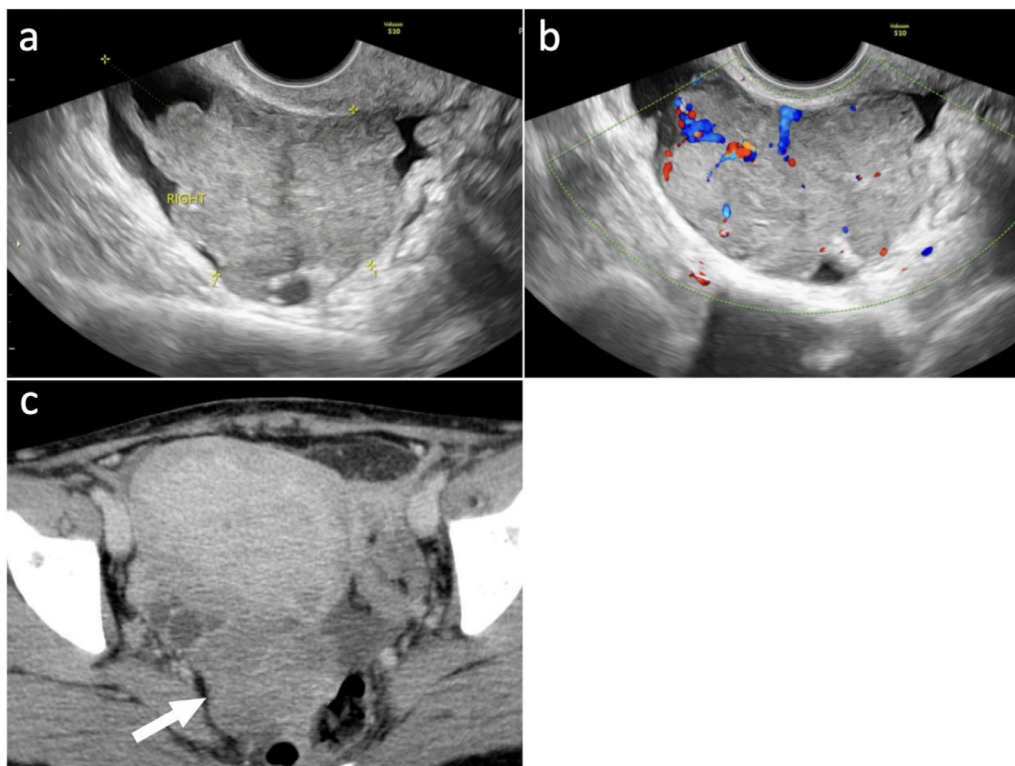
TVUS (A), TVUS with color Doppler (B), and CT with intravenous contrast (C). irregular complex solid-cystic mass measuring 57 × 44 × 72 mm (A) with positive color doppler (B), suspected of being a right malignant ovarian tumor. Homogeneous solid mass located in the Douglas pouch initially suggested a subserosal fibroid (white arrow) (C).
